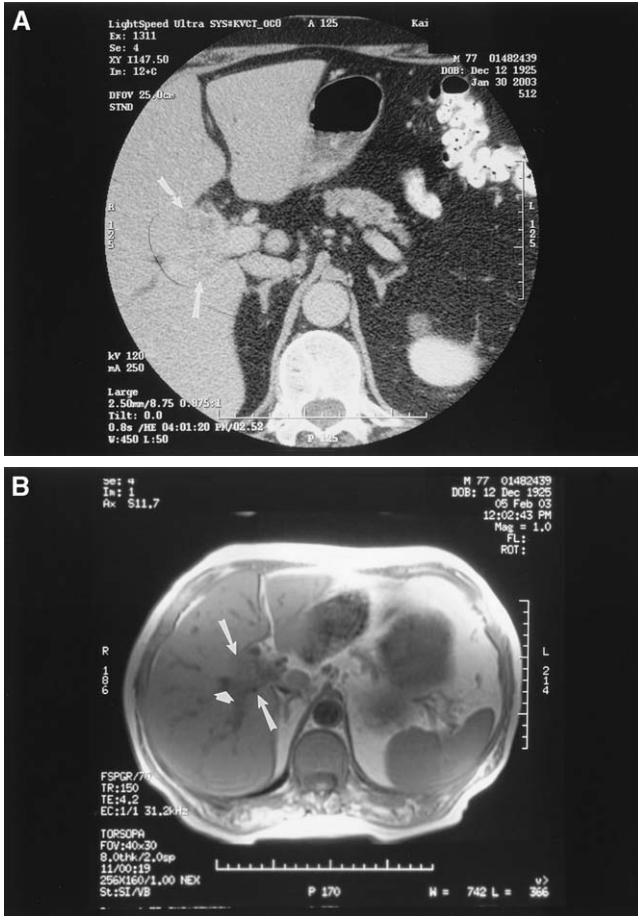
(A) CT scan and (B) MRI in patient with HCCa (same patient as Fig. 1). The CT scan demonstrates an ill-defined hypodense mass in the hilum of the right lobe of the liver (between arrows), whereas the MRI reveals more extensive hepatic parenchymal involvement (between arrows) with invasion of the right main portal vein (arrowhead).
